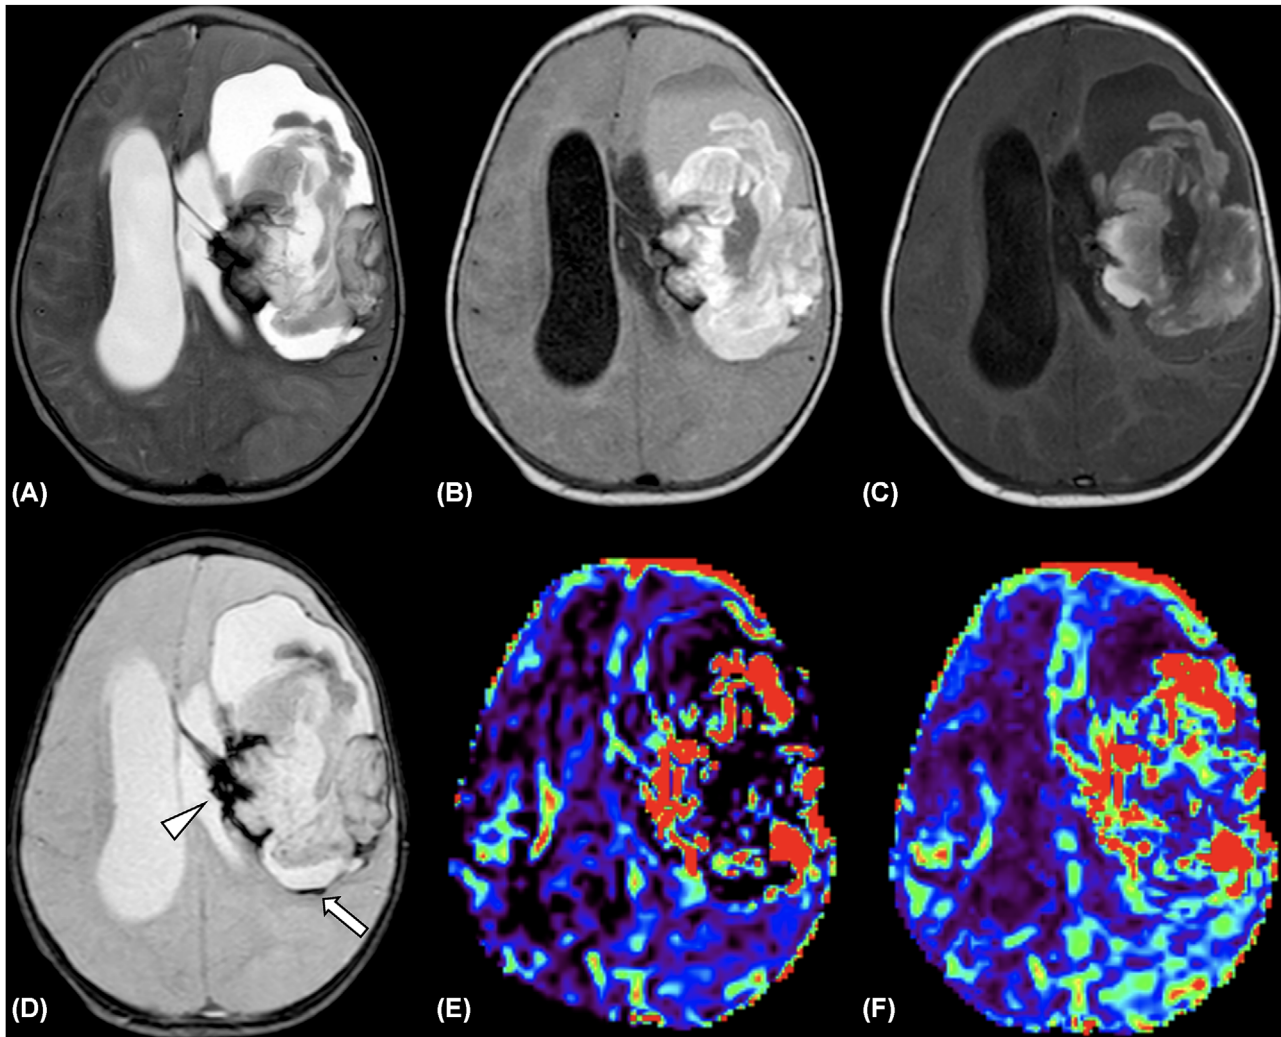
Supratentorial high-grade astroblastoma in a 7-month-old child presenting with eye rotation, fever, and vomiting (patient 8). The solid components of the tumor show mainly high intensity on T2-weighted image (A) and fluid-attenuated inversion recovery (FLAIR) images (B), and high and iso-intensity on T1-weighted image (C). The cystic components show high intensity on T2-weighted image (A) and FLAIR images (B) and low intensity on T1-weighted image (C). A T2*-weighted image shows very low intensity, suggestive of intratumoral calcification (D: arrowhead) and a fluid-fluid level, indicating hemorrhage (D: arrow). The tumor presents as a solid mass with surrounding cysts (morphology I). Dynamic susceptibility contrast perfusion MRI shows elevated relative cerebral blood volume (E) and blood flow (F) in the solid components of the tumor
